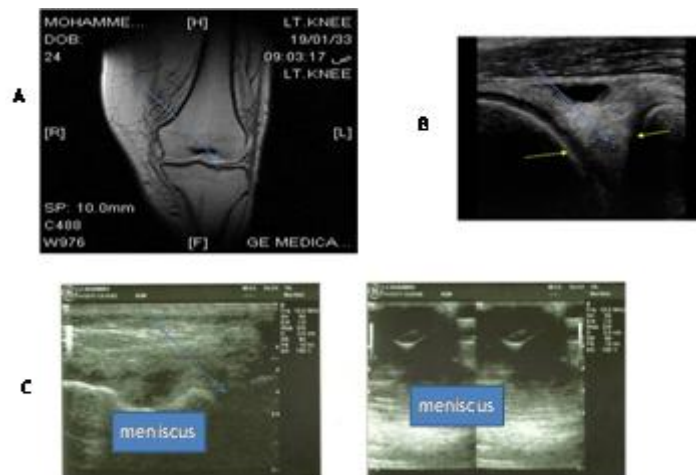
Knee joint Meniscus tear, MRI: A, Ultrasound: B & C
